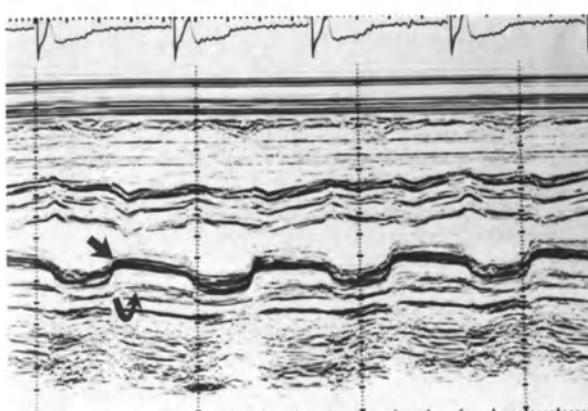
M-Mode echocardiogram of a patient with mitral stenosis showing thickening of the mitral valve cusps (anterior cusp: straight arrow; posterior cusp: curved arrow) with poor opening and slow diastolic closure.
